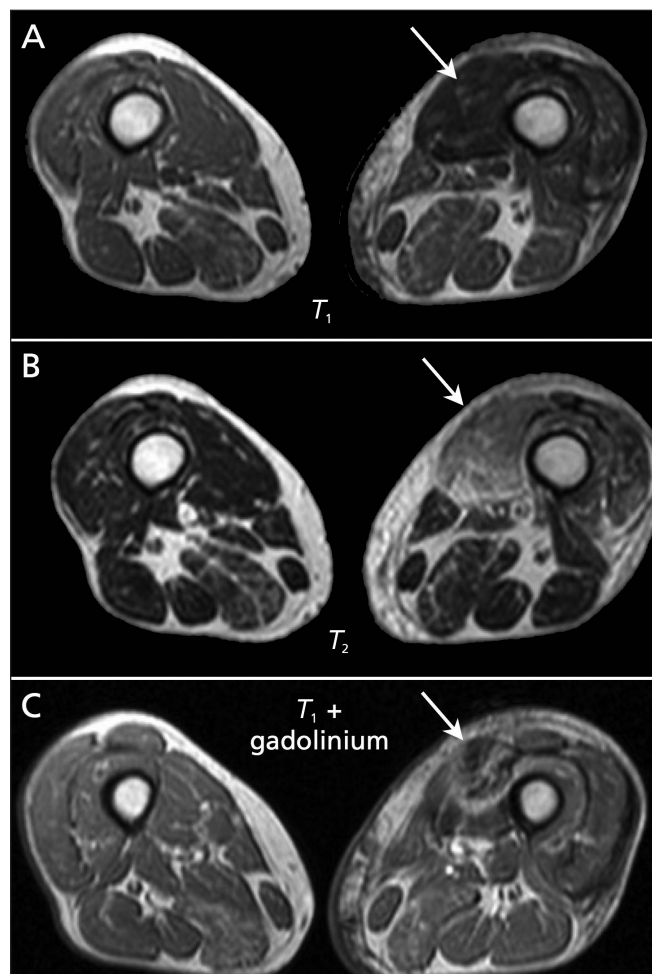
Magnetic resonance imaging of the patient's thighs. A: T_1 -weighted images showing swelling and hypointensity (arrow) of the involved muscle. B: T_2 -weighted images showing diffuse, heterogeneous signal in the involved muscle (arrow), suggesting edema. C: A focal area of heterogeneously enhanced mass (arrow) with peripheral enhancement was visible after administration of gadolinium.
